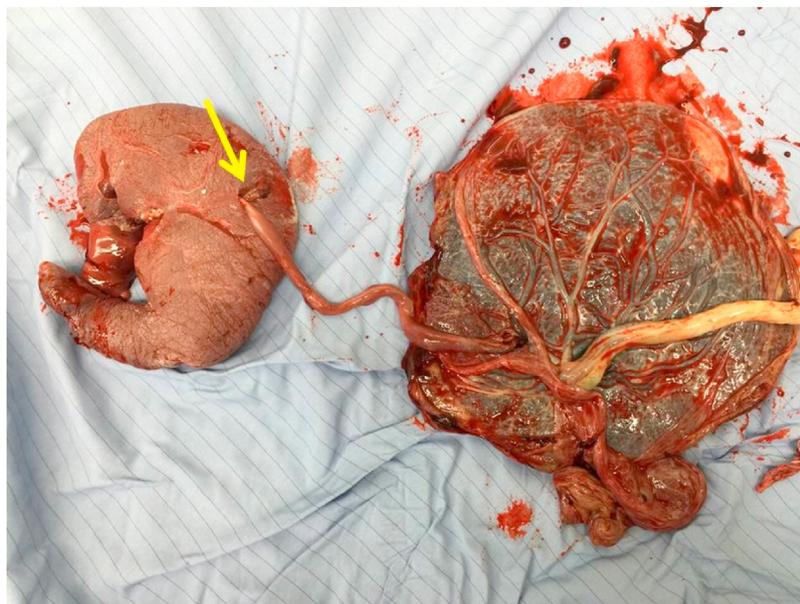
A hypo-hetero-echoic mass with femoral bone (the acardiac monster) without heart activity in ultrasound. (Arrow points to the malformation connected vessels linked to the acardiac monster).
